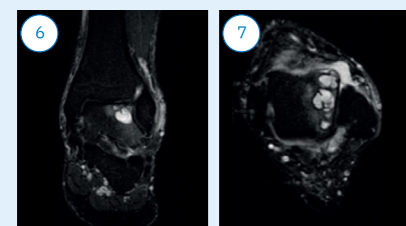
the preoperative MRI
